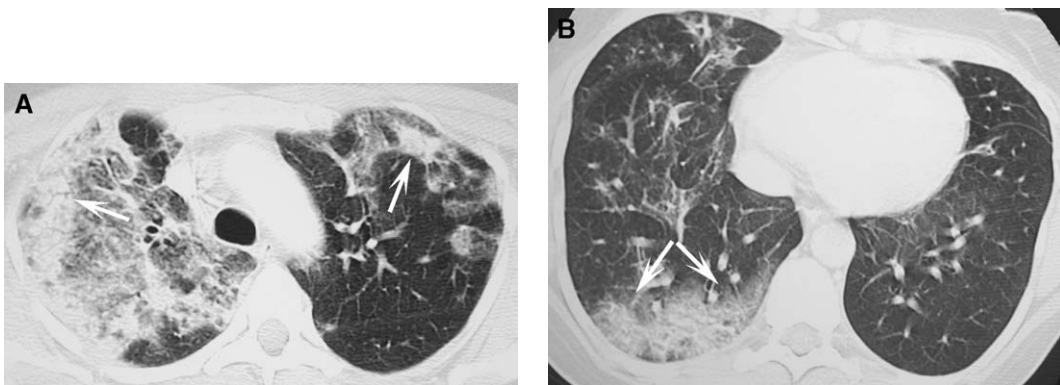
Consolidation on HRCT imaging: chronic eosinophilic pneumonia. Axial HRCT images through the upper (A) and lower (B) lungs show multifocal, bilateral, peripheral consolidations (arrows) highly suggestive of chronic eosinophilic pneumonia or cryptogenic organizing pneumonia. Recognition of the peripheral nature of these opacities prompted bronchoscopy, which showed pulmonary eosinophilia, confirming the diagnosis of chronic eosinophilic pneumonia. The opacities resolved completely 1 week later following steroid treatment.
